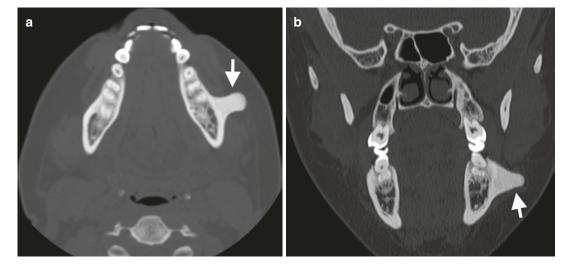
Osteoma in an adult male patient presenting with a slow-growing mass left body mandible. (a) Axial and (b) coronal CT demonstrate a well-demarcated dense "ivory"-like bony lesion attached to an intact cortex
